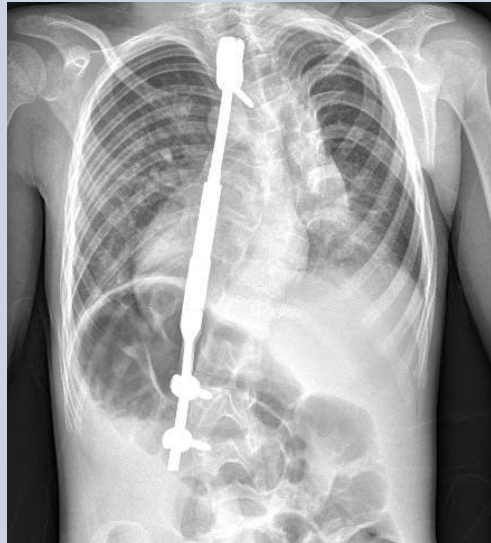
X-ray scan indicating a reduced spinal curvature three months after the implantation of a MAGEC rod.
